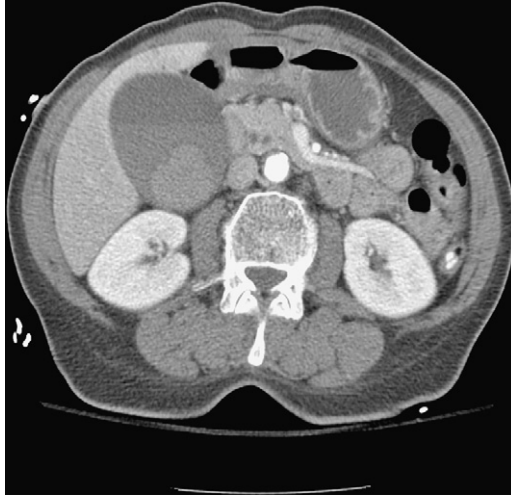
CT of the abdomen revealing a markedly dilated gallbladder containing a globular density compatible with intraluminal blood clot in a patient with severe coronary artery disease, who was receiving aspirin, clopidogrel, and intravenous unfractionated heparin. No gallstones were visualized. At laparoscopic cholecystectomy an acutely inflamed gallbladder was resected. Clot was present in the lumen, but no stones.
